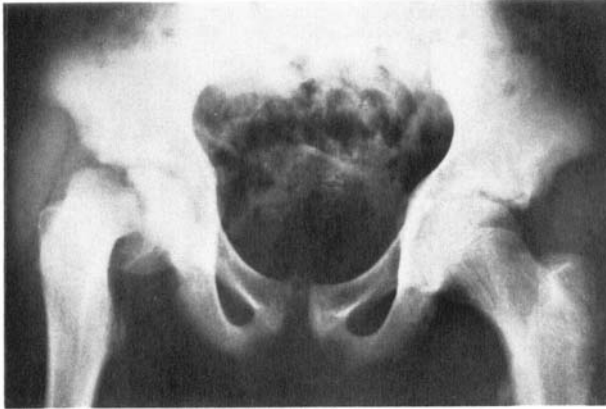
a. Roentgenological examination of both hip joints of a 15-year-old boy (No. 3), 1 day after minor trauma to the right hip, showing pronounced slipping on the right side.
